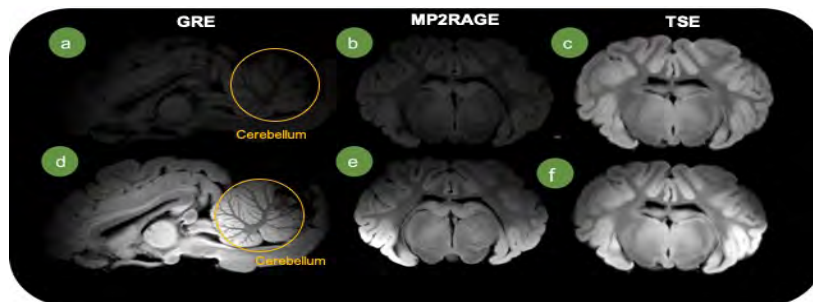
Top row shows MR images obtained without the RF array and bottom row shows MR images obtained in the presence of the RF array. The base of skull and cerebellum are more clearly visible in the presence of the array with about 4-fold SNR improvement.
